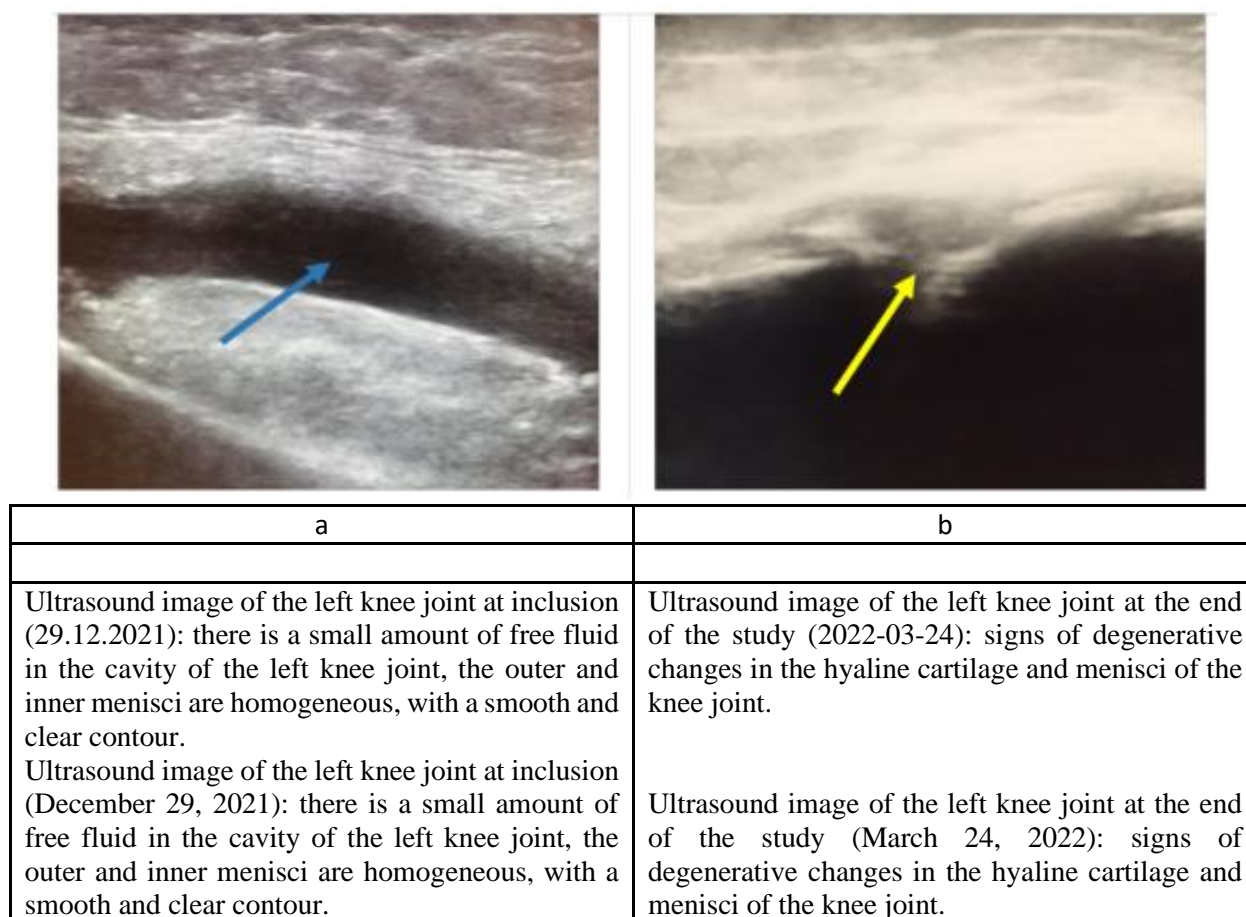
Ultrasound image of the knee joints of patient G., 43 years old, while taking Placebo
